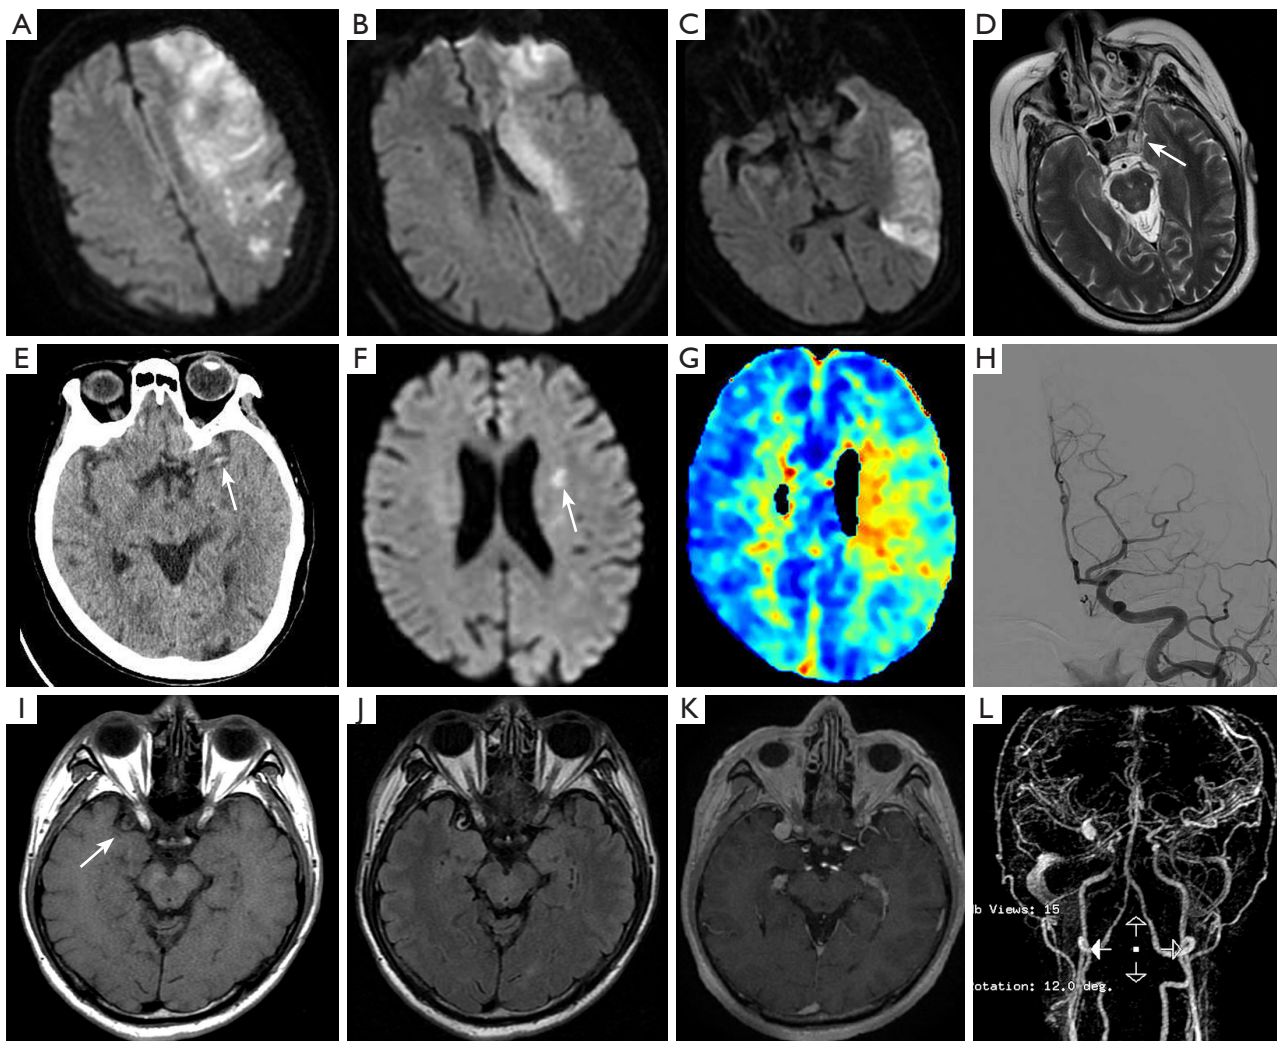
Blind spot in brain imaging: intracranial arteries. (A-D) Scans of a 49-year-old female after endometrial cancer surgery. During the follow-up period, the patient developed neurological symptoms such as excessive sleepiness, muscle weakness, sensory loss, an inability to frown and protrude the tongue, and the disappearance of the nasolabial fold, which highly indicated an intracranial lesion. (A-C) MRI showed multiple wedge-shaped and patchy abnormal signal lesions in the blood-supply area of the left anterior and MCAs. The lesions were hyperintense in T₂WI/FLAIR and DWI, suggesting a diagnosis of cerebral infarction. (D) Additionally, abnormal signals in the internal carotid artery were observed in the region of the cavernous sinus (arrow), suggesting thrombus formation. (E-H) Scans of a 73-year-old female with left-sided cerebral infarction. (E) CT showed the hyperdense sign in the middle cerebral artery (arrow). (F) DWI showed high signal lesions on the left side (arrow), (G) PWI showed prolonged MTT in the left cerebral hemisphere, and (H) DSA showed middle cerebral artery stenosis. (I-L) Scans of a 63-year-old male with eminence of the left face accompanied by reduced facial sensation after radiotherapy for right maxillary sinus cancer. (I-K) The aneurysmal dilation near the orbital apex adjacent to the right cavernous sinus was shown by MRI (arrow). (L) Ultimately, brain MRA showed an aneurysm in the M1 segment of the middle cerebral artery. MRI, magnetic resonance imaging; MCA, middle cerebral artery; T₂WI/FLAIR, T2-weighted image/fluid-attenuated inversion recovery; DWI, diffusion-weighted imaging; CT, computed tomography; PWI, perfusion weighted imaging; MTT, mean transit time; DSA, digital subtraction angiography; MRA, magnetic resonance angiography.
